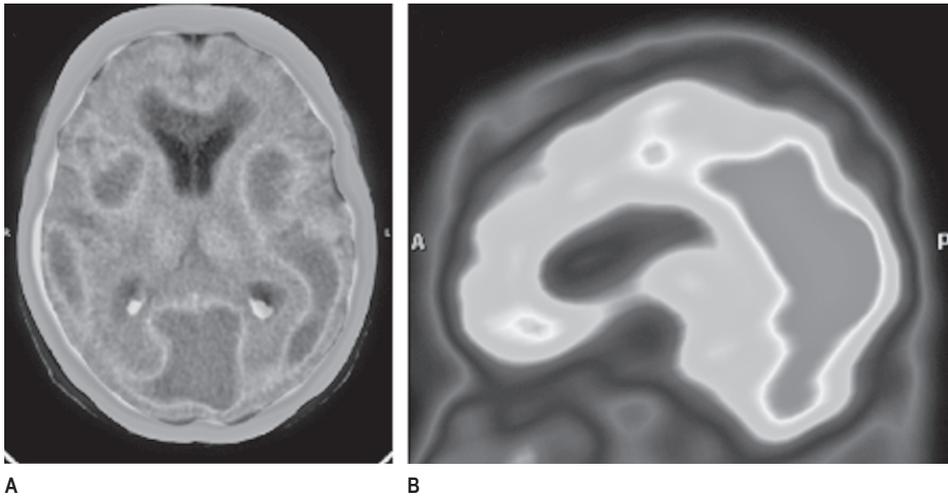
SPECT image of the brain: A – axial SPECT/CT fused image; B – sagittal SPECT image
